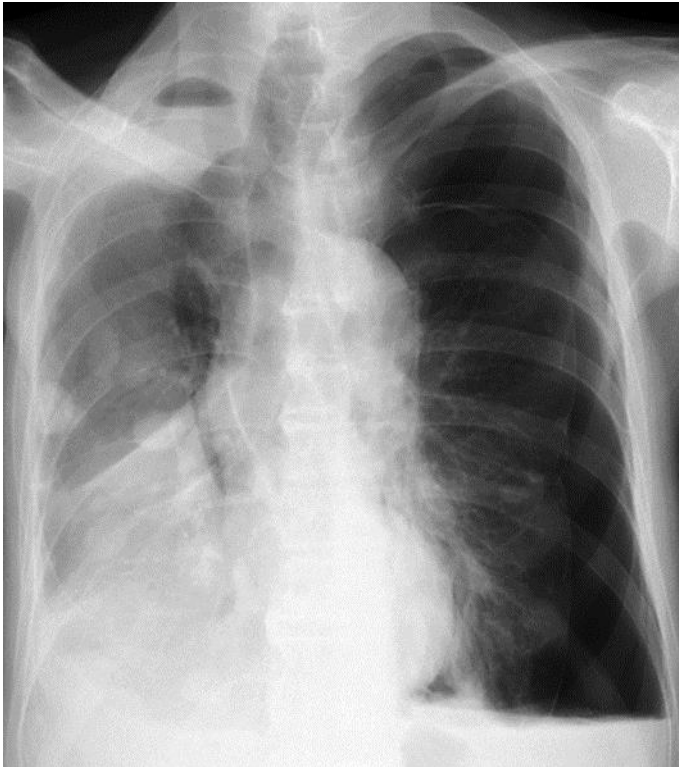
Chest X-ray demonstrating multiple lung metastases of sarcoma and a metastasis to the right pleura and left hemopneumothorax.
